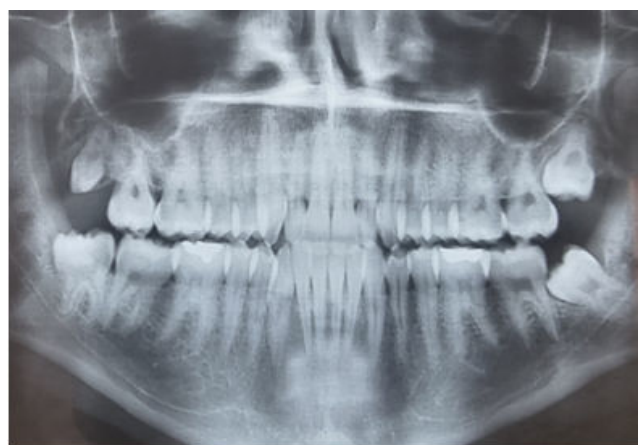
Panoramic radiograph revealing no alveolar bone loss.
